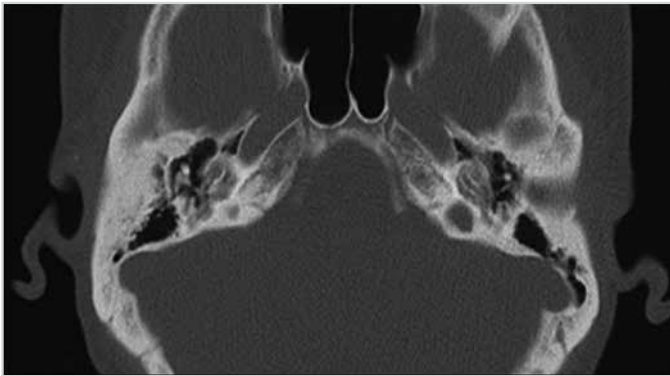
Temporal bone computed tomography revealing severe demineralization around the cochlea and the vestibule
